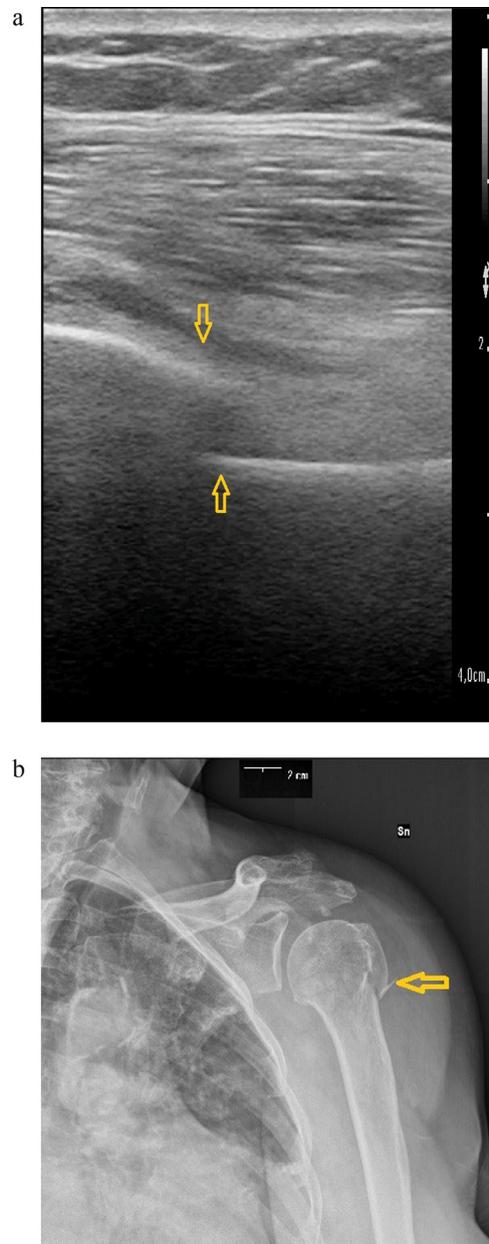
(a) Ultrasound image of humerus fracture. *Yellow arrows* point to bones out of place at the joint connecting them. (b) X-Ray image of humerus fracture. *Yellow arrow* points to bones out of place at the joint connecting them.
